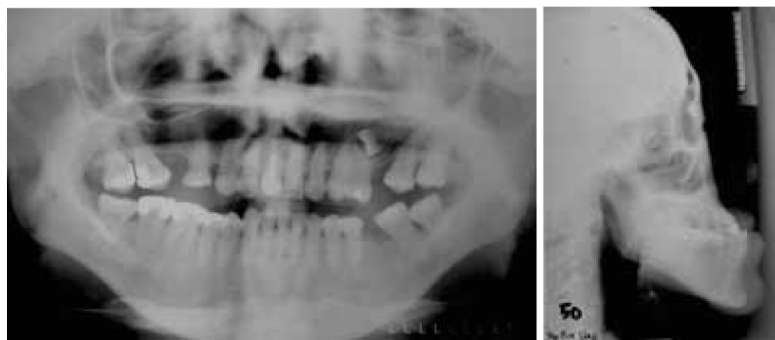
Pre-treatment radiographs A) Panoramic B) Lateral Cephalometric. Notice the position of impacted 25 is very high. The sagittal discrepancy shows severe hypoplastic maxillary and hyperplastic mandible on a high maxillo-mandibular plane angle
